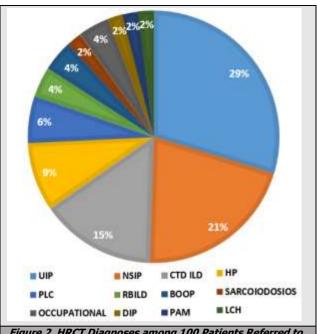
HRCT Diagnoses among 100 Patients Referred to BMCH for HRCT Chest with the Provisional Diagnosis of ILD
